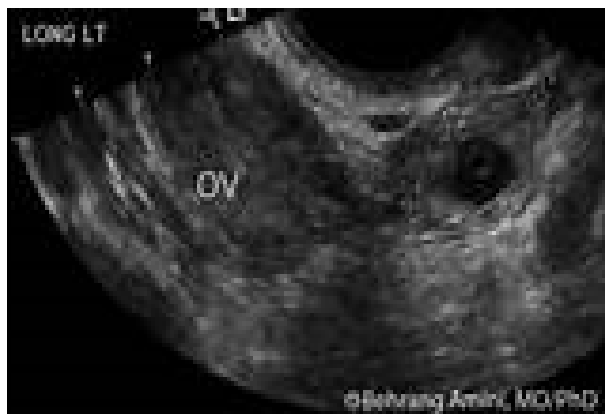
Image No-1: Ultrasound showing ovarian ectopic pregnancy
